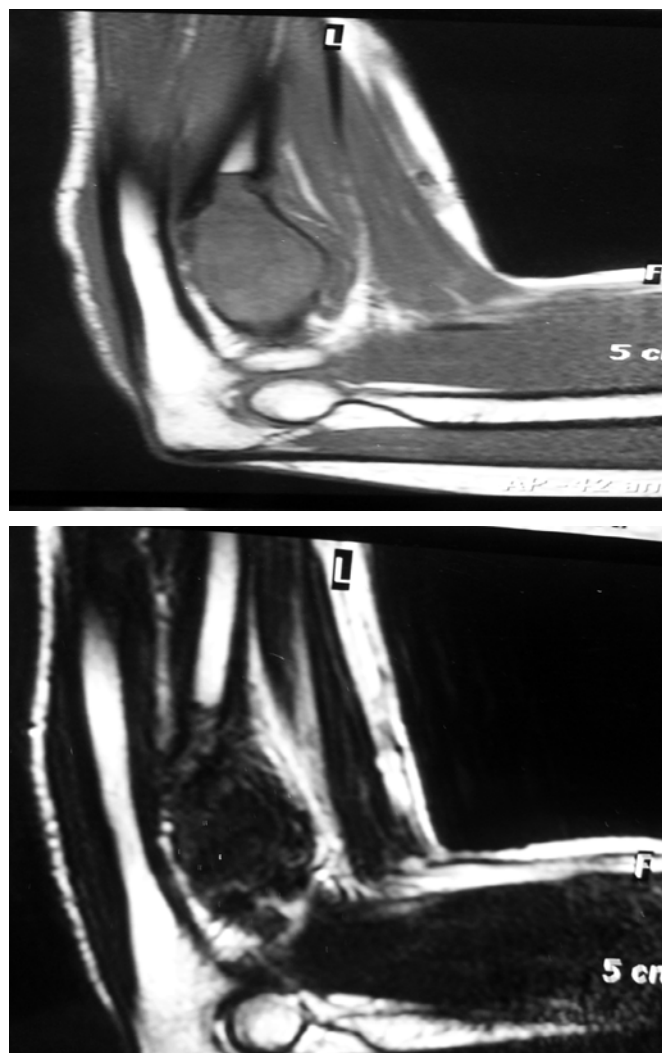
3 MRI of elbow showing Isointense lesion on T1 and Hypointense lesion on T2
